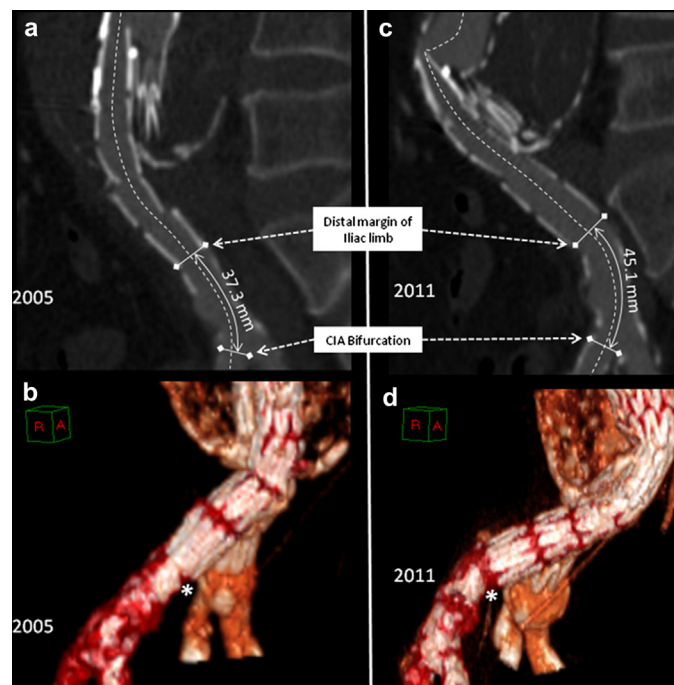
A central luminal line (CLL) (a) and three-dimensional (3D) volume-rendered (VR) images (b) from the 2005 first postoperative follow-up computed tomography (CT) scan, the distal portion of the left iliac limb was sitting 37.3 mm above the bifurcation of the right common iliac artery (CIA). By 2011 the limb had moved cranially 7.8 mm, the distal margins of the device are now resting 45.1 mm above the CIA bifurcation (c). On the VR images (d) cranial movement of the device between the two time points can clearly be seen in relation to vascular calcification (*).
